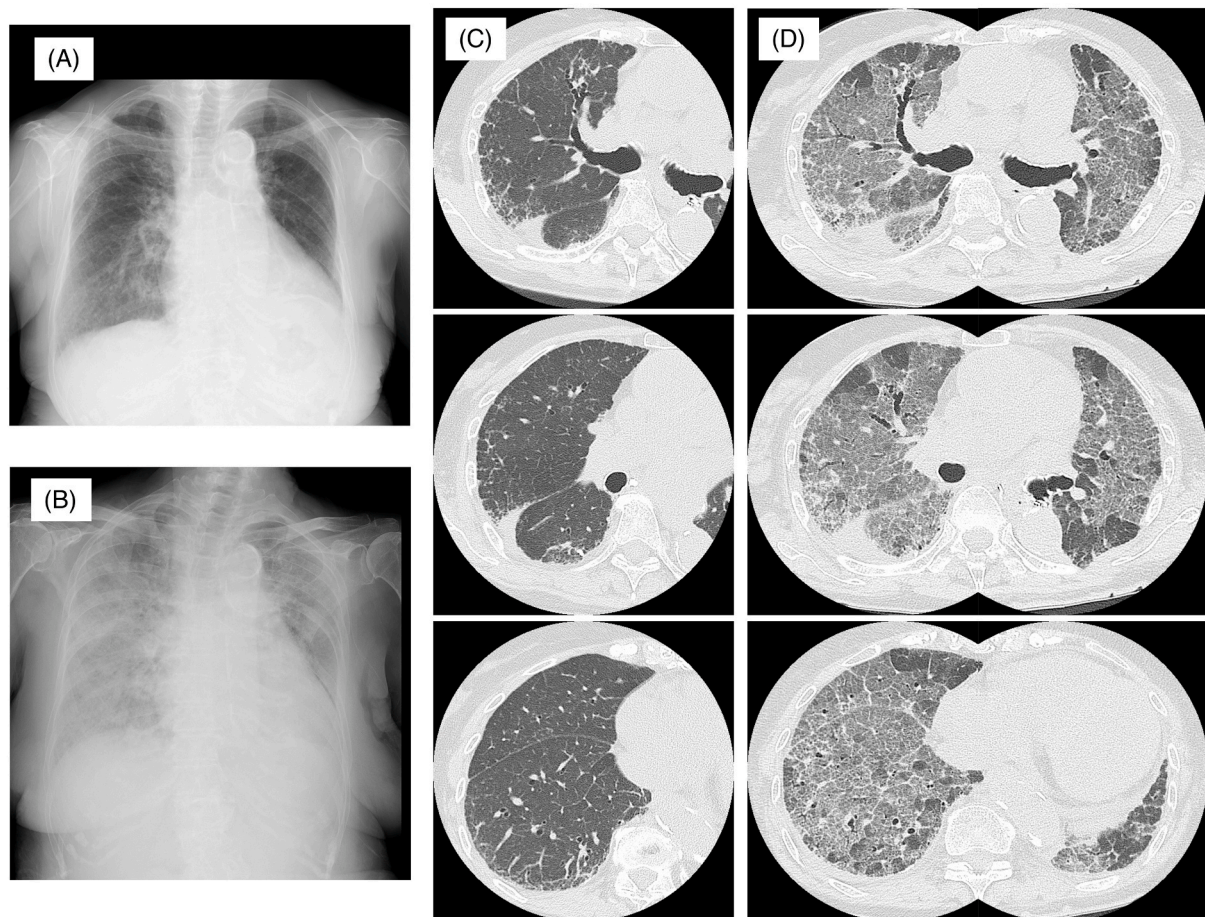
Radiographic images of case #1. Chest X-ray images of the patient (A) before and (B) at the diagnosis of acute exacerbation of interstitial lung disease. Chest CT images of the patient (C) before and (D) at the diagnosis of acute exacerbation of interstitial lung disease.
